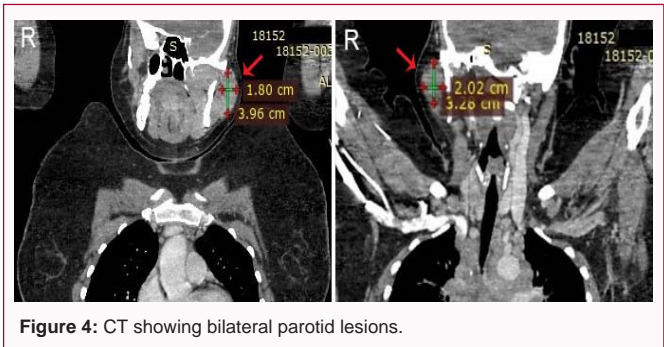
CT showing bilateral parotid lesions.
